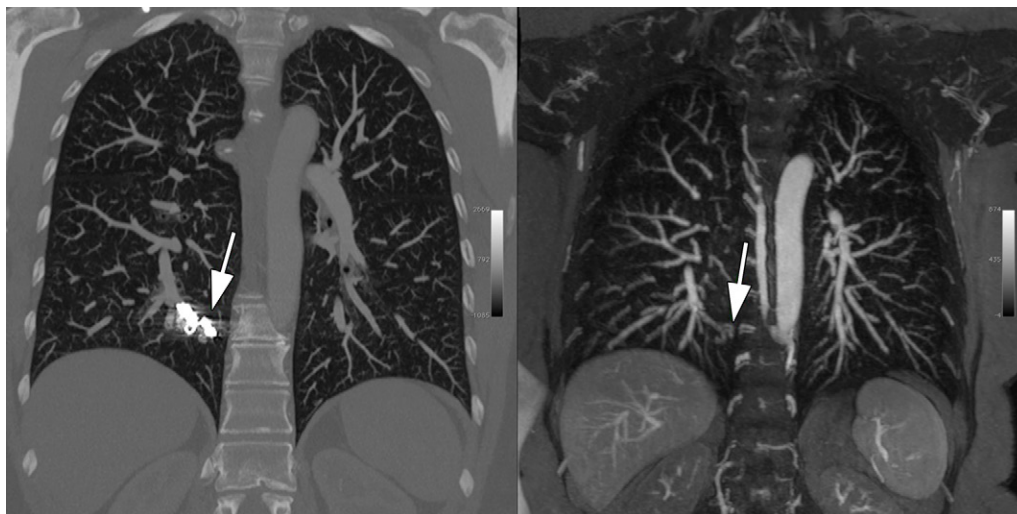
Coronal CT angiogram (left) in a 50-year-old woman with hereditary hemorrhagic telangiectasia, who underwent prior coil embolization of a pulmonary arteriovenous malformation in the medial right lower lobe. Beam-hardening artifact related to the metallic coils (arrow in left panel) obscures the presence of recanalization that is demonstrated by the MR angiogram with ferumoxytol (arrow in right panel) and is void of beam-hardening artifact.
